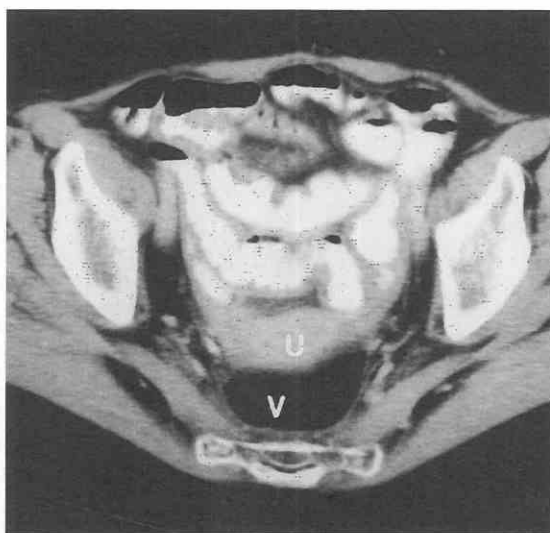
Postradiation enteritis. CT scan through the pelvic small bowel, diffusely thickened in a woman who had undergone radiation therapy for cancer of the rectum. The uterus (U) is displaced backward into the surgical void (V).
